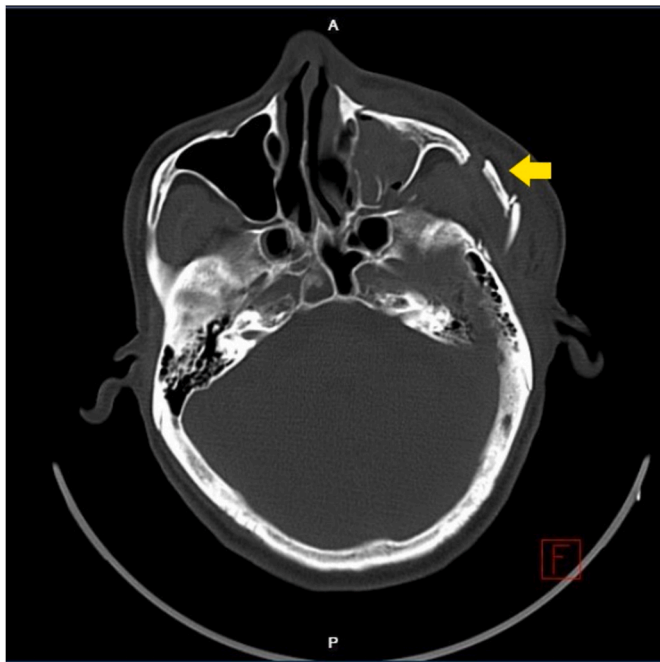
A fracture of the left cheekbone is revealed by computed tomography of the brain (yellow arrow).
